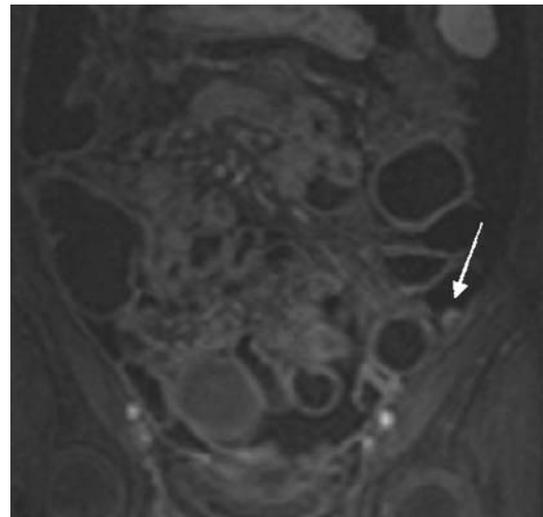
A postcontrast T1-weighted coronal source image from a 65-year-old woman with sigmoid diverticulitis. In the descending colon a contrast enhancing lesion (*arrow*) with a diameter of 10 mm is seen which was confirmed by CC
